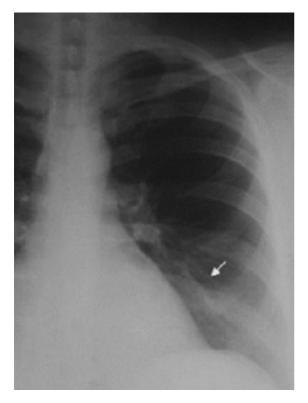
Case 2. Chest X-ray showing mild left lung basal infiltrate
